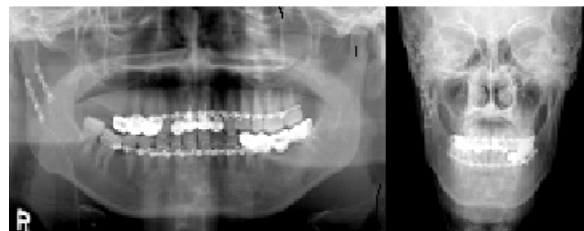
Postoperative panoramic and PA radiograph. Anatomical reduction and fixation was achieved.
